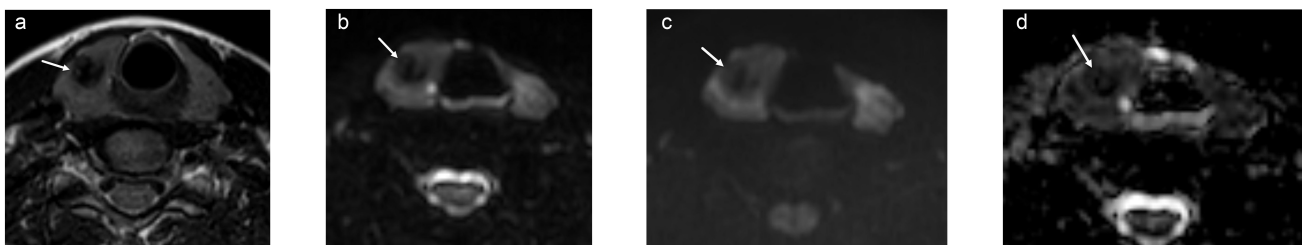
A 24-year-old female with a right thyroid nodule. On FNA biopsy, atypia of undetermined significance (Bethesda category III) was reported. (A) T2-weighted image shows a hypointense solitary nodule in the right lobe of the thyroid gland (arrow). The nodule-to-muscle T2-weighted signal intensity ratio is 0.36. (B-C) DWI images at b=0 and b=1000. (D) ADC map showing the thyroid nodule with an ADC value of 0.856 and nodule-to-spinal cord ADC ratio 0.696. The final surgical diagnosis was papillary thyroid carcinoma. FNA, fine-needle aspiration; ADC, apparent diffusion coefficient; DWI, diffusion-weighted images.
